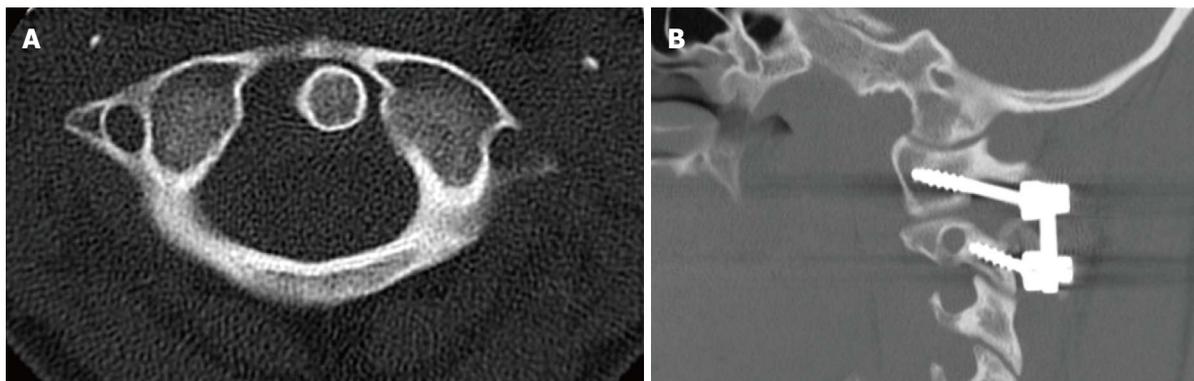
C1 lateral mass fixation. A: Axial computed tomography (CT) cut through the atlas. Note the lateral masses and the relationship of the C1 arch meeting the lateral masses which are landmarks for correct starting points for lateral mass screws; B: Sagittal cut of a CT scan in a 14 year-old patient who has underwent C1-C2 arthrodesis with C1-C2 screw rod construct for an odontoid non-union. Note the starting position of the C1 lateral mass screw inferior to the bony arch of C1. The outline of the vertebral artery can be seen on the superior aspect of the C1 arch.
